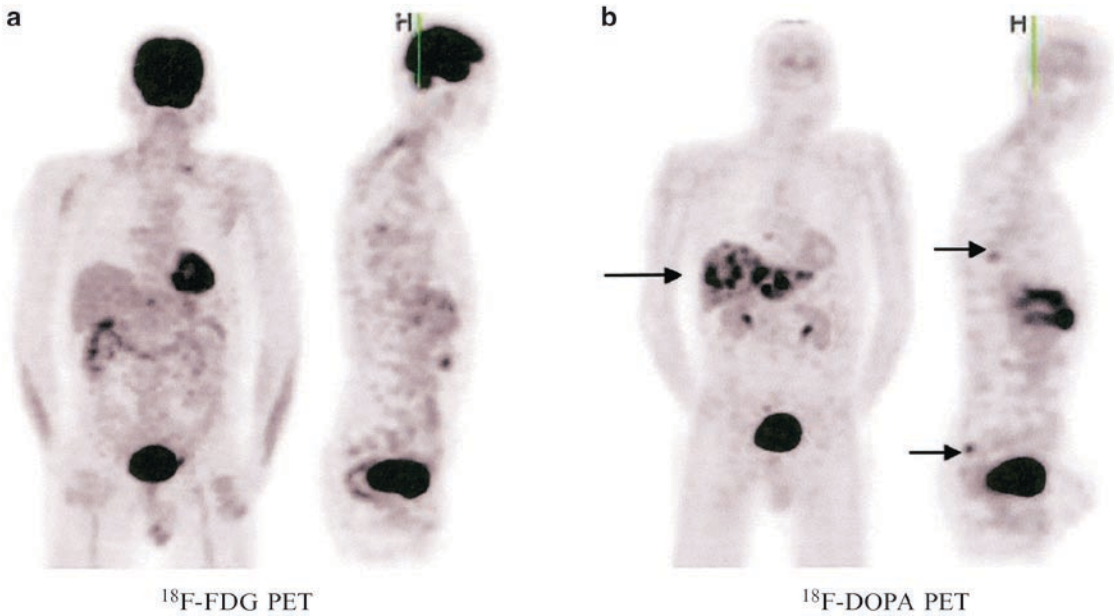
These are the images of a patient known with medullary thyroid cancer. In this patient ^{18}F -FDG PET (a) and ^{18}F -DOPA PET (b) were performed. The
